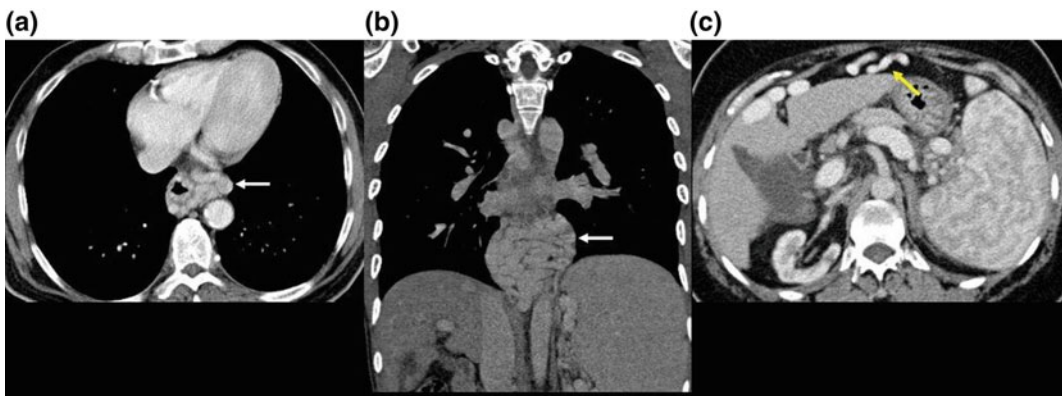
Axial and coronal images from an enhanced CT scan (a, b) showing esophageal varices (white arrow). Axial image from an enhanced CT scan (c) showing a recanalized umbilical vein (yellow arrow)
